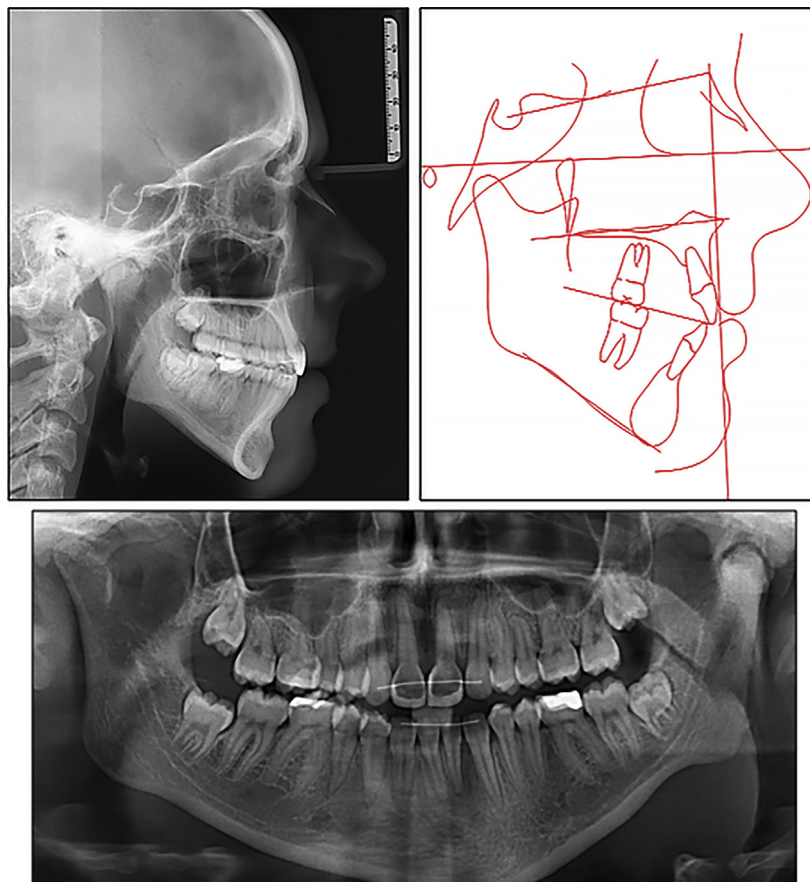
Posttreatment lateral radiograph with cephalometric tracing and panoramic radiograph.
